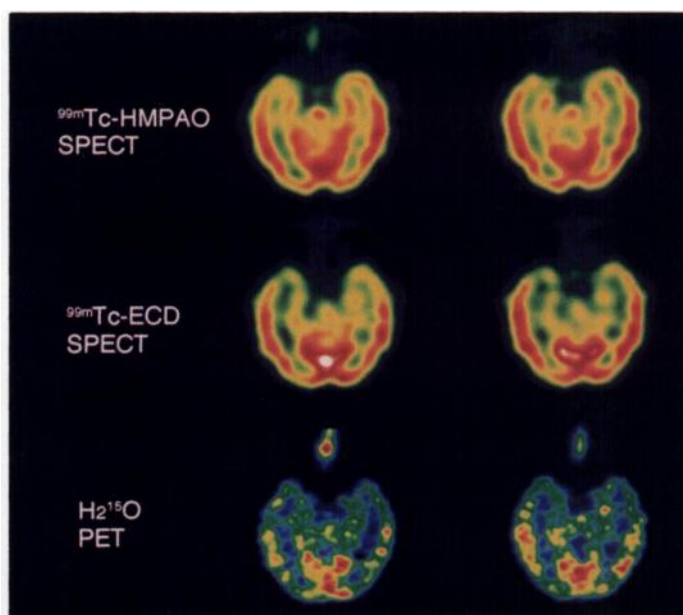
Comparison of hippocampal plane images among ^{99m}Tc -HMPAO SPECT, ^{99m}Tc -ECD SPECT and H_2^{15}O PET. A 41-yr-old healthy man had two SPECT studies and a H_2^{15}O PET study. There was considerable discrepancy in visualizing the medial temporal lobes between ^{99m}Tc -labeled tracers. The rCBF distribution measured by PET, H_2^{15}O bolus injection and autoradiography was compared. Relative activity of ^{99m}Tc -HMPAO and ^{99m}Tc -ECD and the relative blood flow in the medial temporal lobe measured by SPECT and PET were 97%, 88% and 92% of the global cerebral cortex, respectively.
